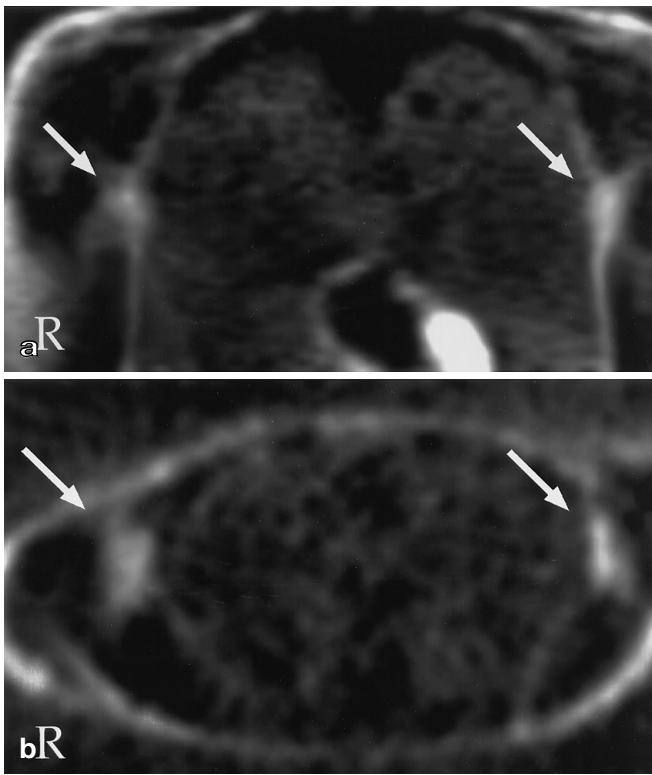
a, b. Uptake of [^{18}F]-FDG in the axillary sweat glands (arrows) of a diabetic male during profuse sweating due to hypoglycaemia at PET examination. a Coronal section; b transverse section. Section level is indicated in the opposite image
